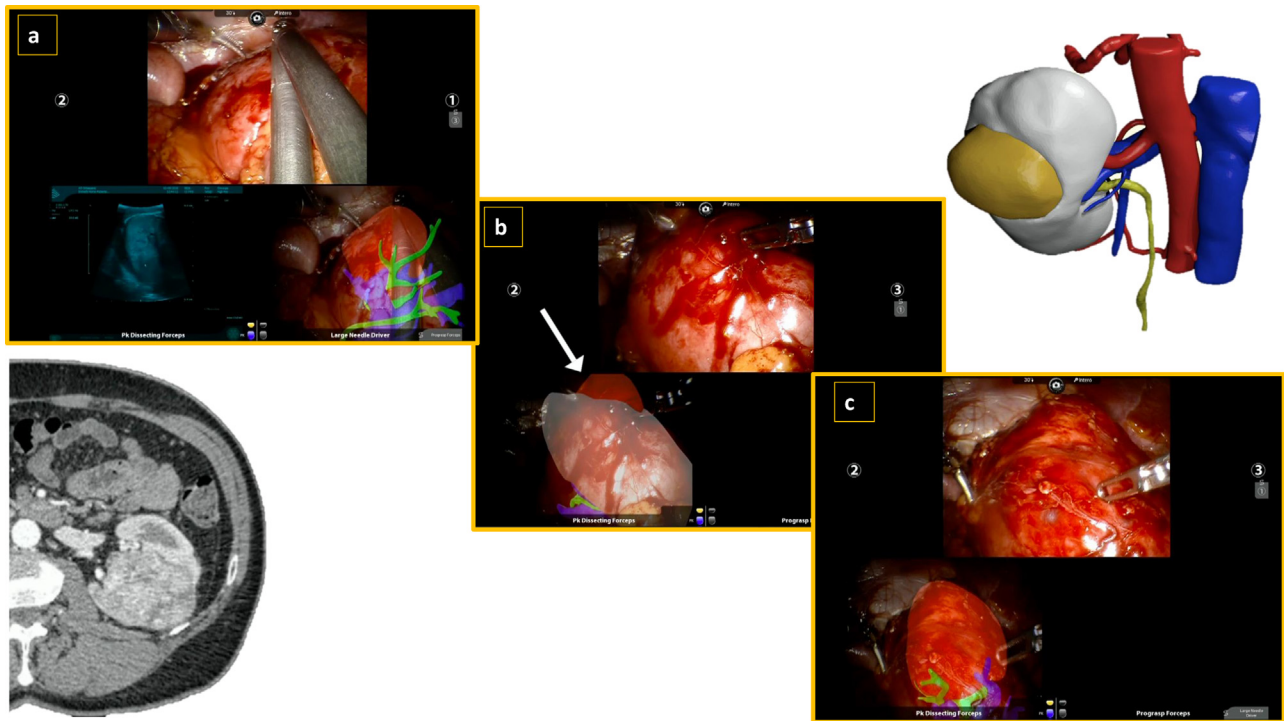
(A) Before kidney rotation, the lesion location was identified by AR images and confirmed with US. (B) During kidney rotation, the lesion arose from the posterior face. (C) After kidney rotation, the lesion location was identified with AR images. AR=augmented reality; US=ultrasound.
